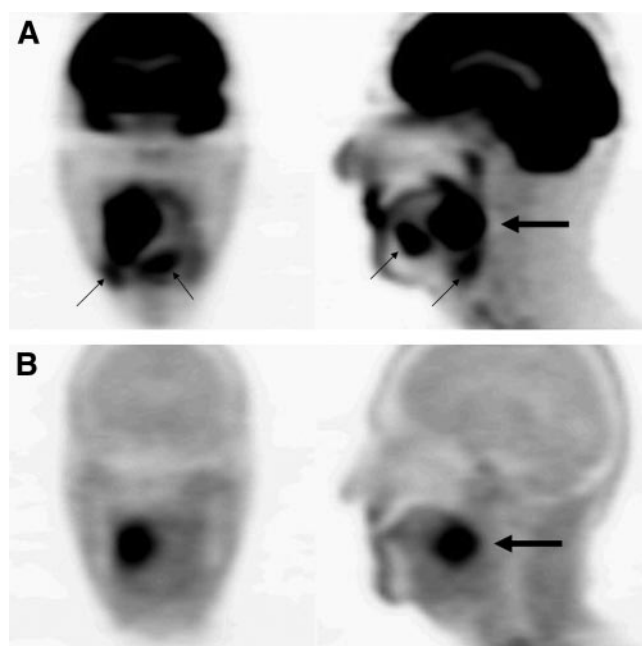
^{18}F -FDG PET (A) and ^{18}F -FET PET (B) of 61-y-old man with cancer of tongue (squamous cell carcinoma). Increased ^{18}F -FDG uptake was noted in tumor (large arrow), and additional uptake was demonstrated in inflammatory tissues (small arrows). Increased ^{18}F -FET uptake was noted only in tumor (large arrow).
